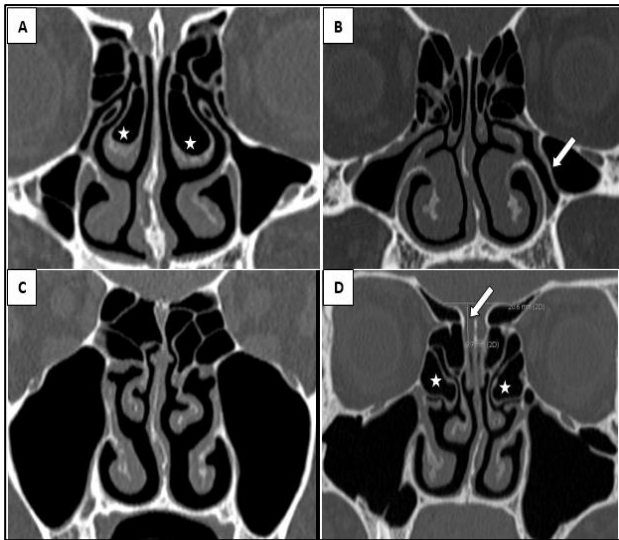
(A) Concha bullosa - Coronal CT scan shows pneumatization of bulbous as well as lamellar portions of bilateral middle turbinates, called as “True concha bullosa” (*). Also note pneumatization of bilateral uncinate processes. (B) Lamellar concha - Pneumatization of vertical lamellar portion of bilateral middle turbinates. Note the left septated maxillary sinus (←) showing intra-sinus bony septum extending from infra-orbital foramen to the lateral maxillary wall. (C) Paradoxical bilateral middle turbinates. (D) Bilateral large ethmoid bulla (*) seen above the infundibula, right one forcing its way between the uncinate process and the middle turbinate. Also note bilateral medialized uncinate processes and Keros type III (8-16mm) deep olfactory fossa (←) usually vulnerable to iatrogenic injury during surgery. Incomplete intra-sinus septations also noted in right maxillary sinus (Figure A) and in both maxillary sinuses (Figure D).
